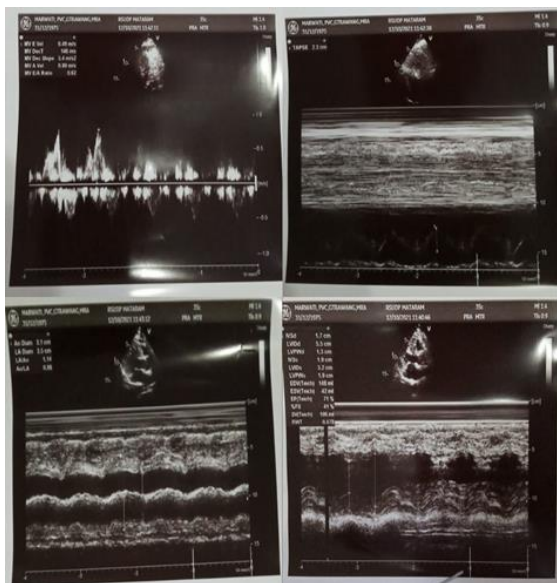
Echocardiography examination showed normal heart chamber, diastolic dysfunction grade I, and concentric left ventricular hypertrophy.
